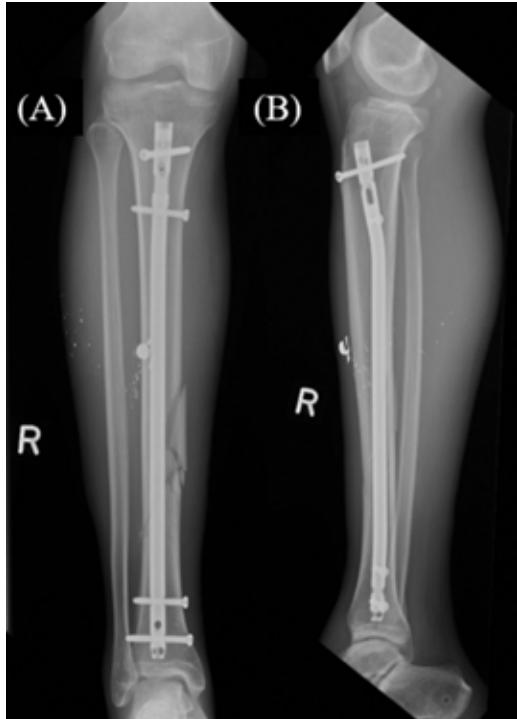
Six-week postoperative (A) AP and (B) lateral radiographs that show the tibia IMN in good position and interval callus formation at the fracture site.
